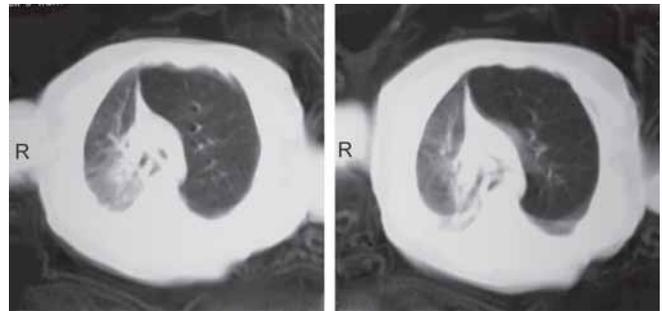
CT appearance in CLE
